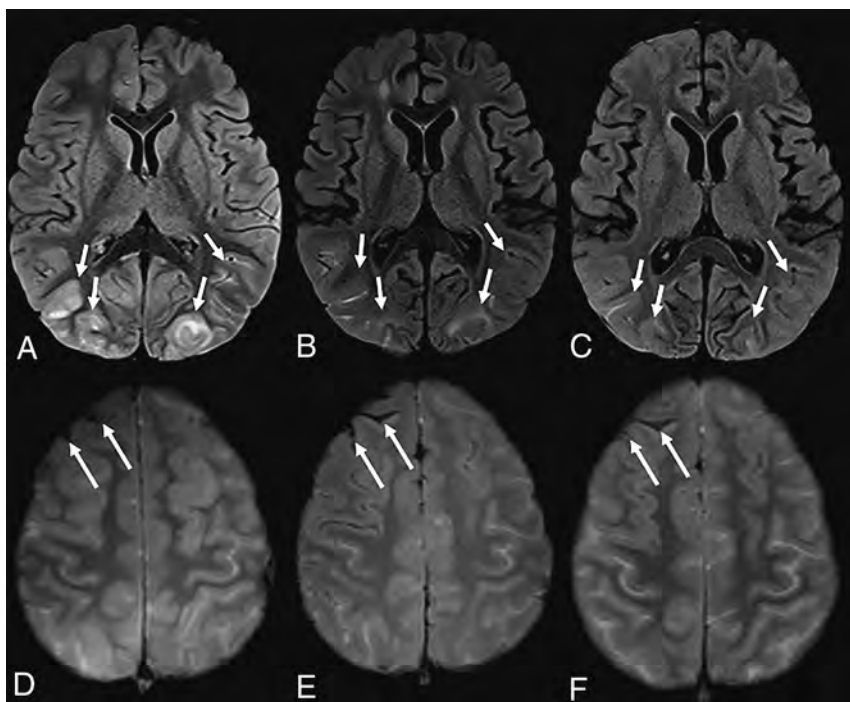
A 7-year-old boy with sickle cell disease who presented with dyspnea and chest pain tested positive for SARS-CoV-2. The patient was unresponsive, having desaturations and being intubated. Brain MR imaging showed T2-FLAIR hyperintensity and cortical edema in the occipital lobes, consistent with posterior reversible encephalopathy syndrome, partially resolving on subsequent imaging (A–C, arrows). Note interval evolution of right frontal subarachnoid hemorrhage (D–F, arrows).
